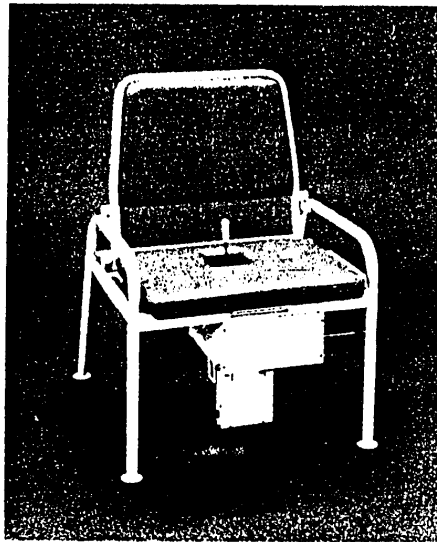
Chair for transrectal sonography
